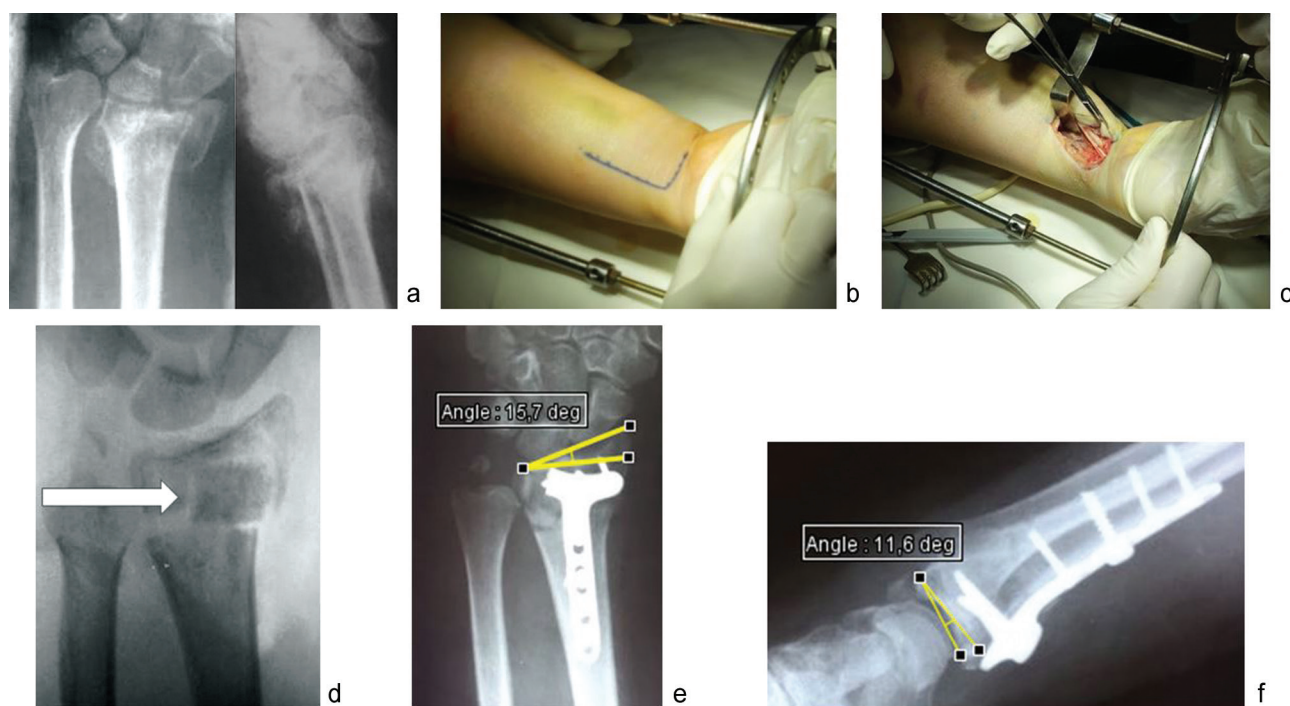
Radiographs and stages of surgical treatment of a 54-year-old female patient K. (intraoperative photographs) showing (a) anteroposterior and lateral views of DRF AO/ASIF type C2.1 and D.L. Fernandez type III, RIA of 3.7° and RTA of 20.4°; (b) L-shaped approach with blue marker; (c) a stage of DRF reduction; (d) image intensifier of DRF after substitution of the defect with xenoplastic graft (an arrow); (e) anteroposterior view of DRF demonstrating congruence of radiocarpal joint restored; (f) lateral view of DRF demonstrating congruence of radiocarpal joint restored, osteosynthesis produced with LCP plate; RIA of 15.7° and RTA of 11.6°
